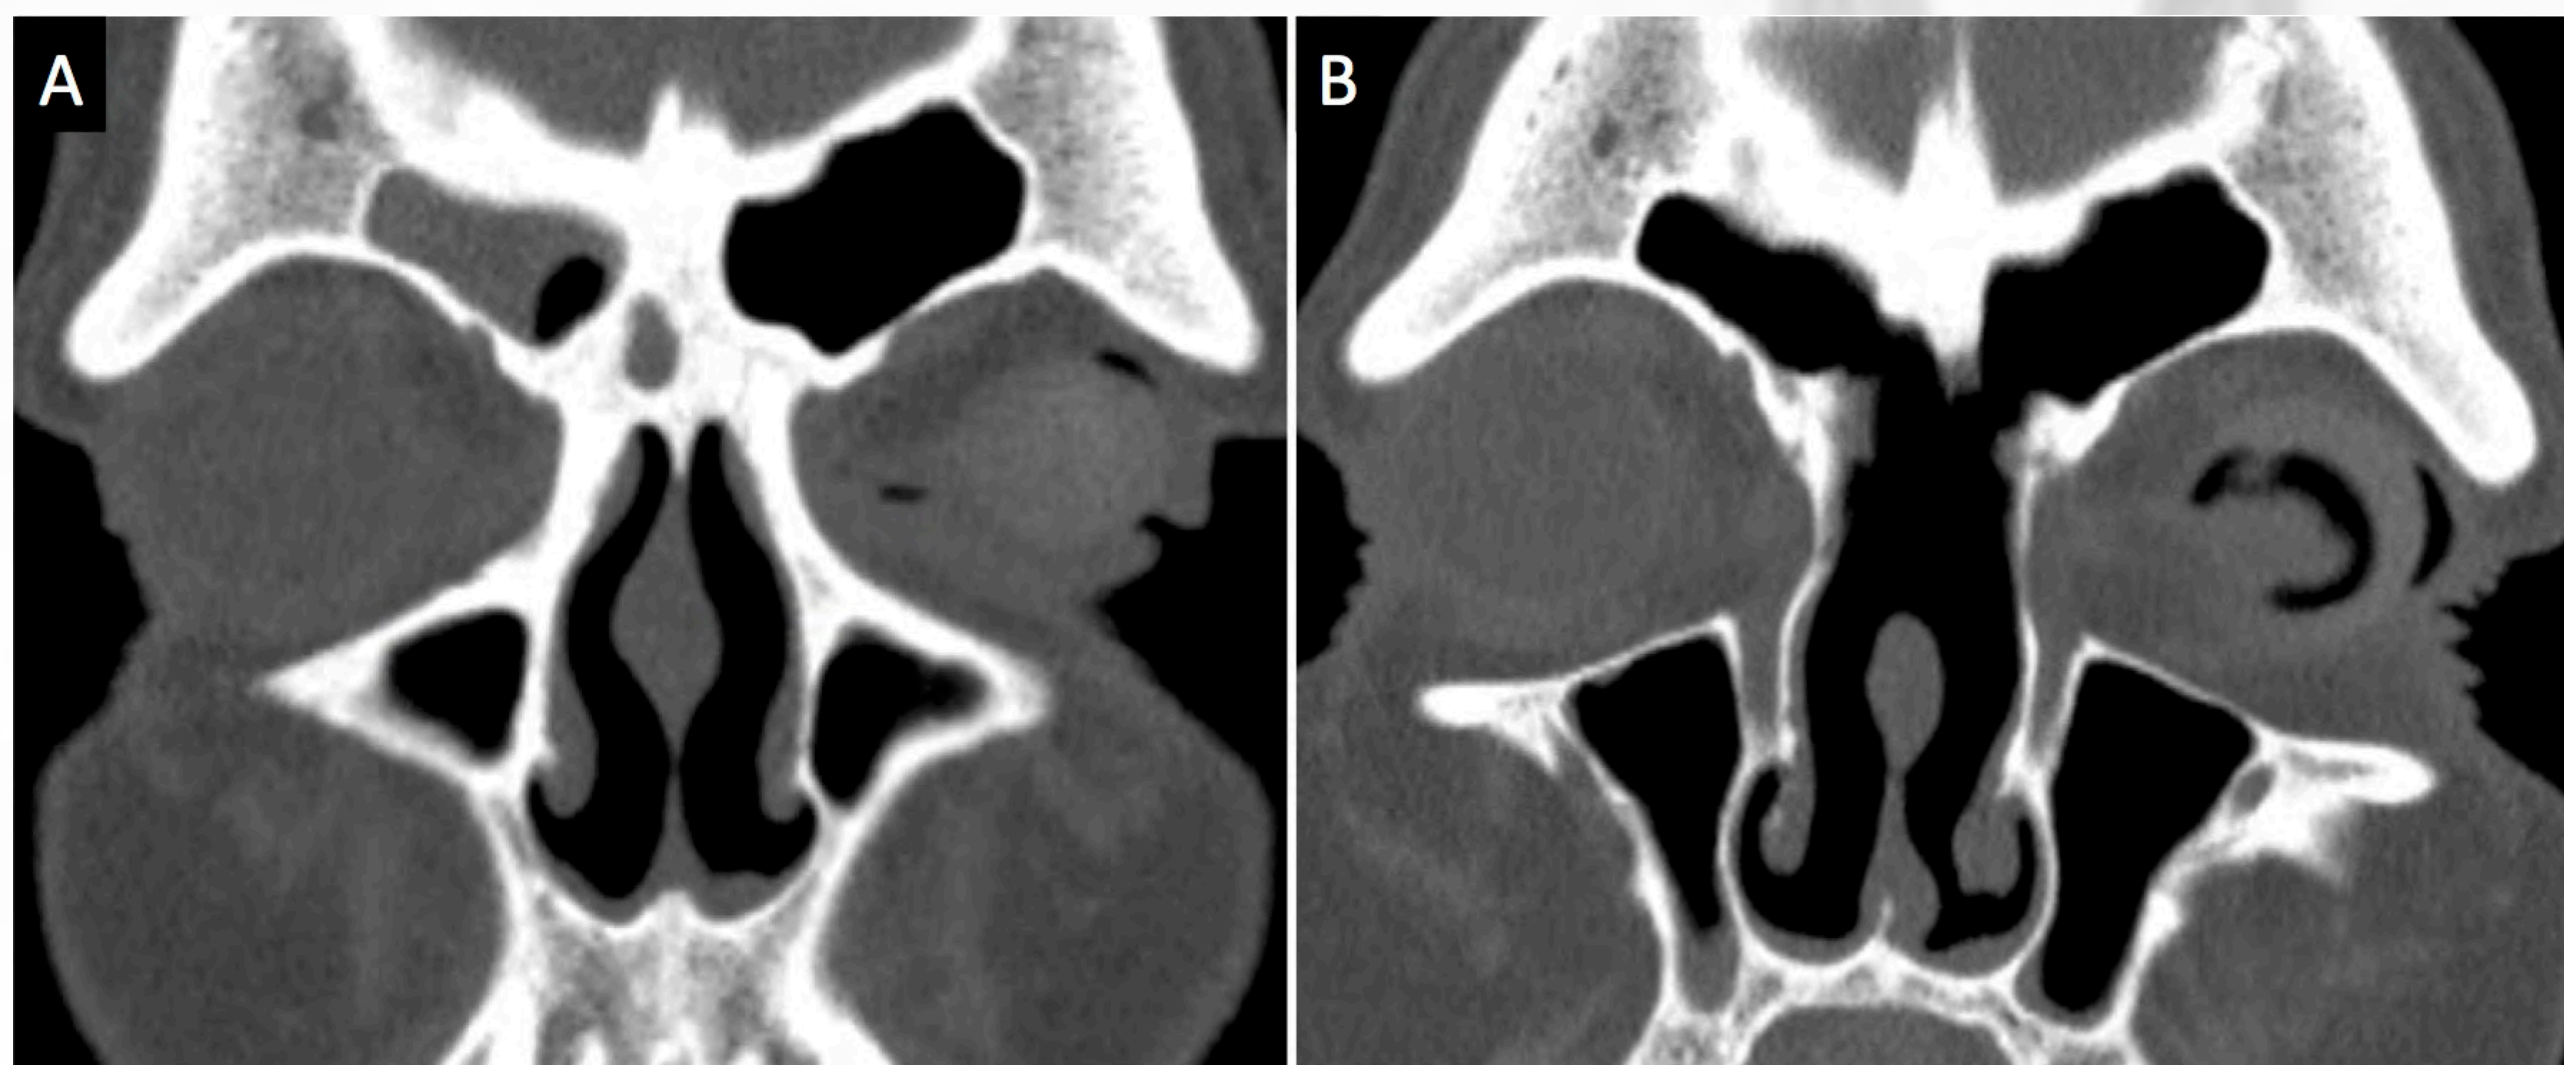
Pre (A) and post (B) Draf III procedure coronal CT images of sinuses
